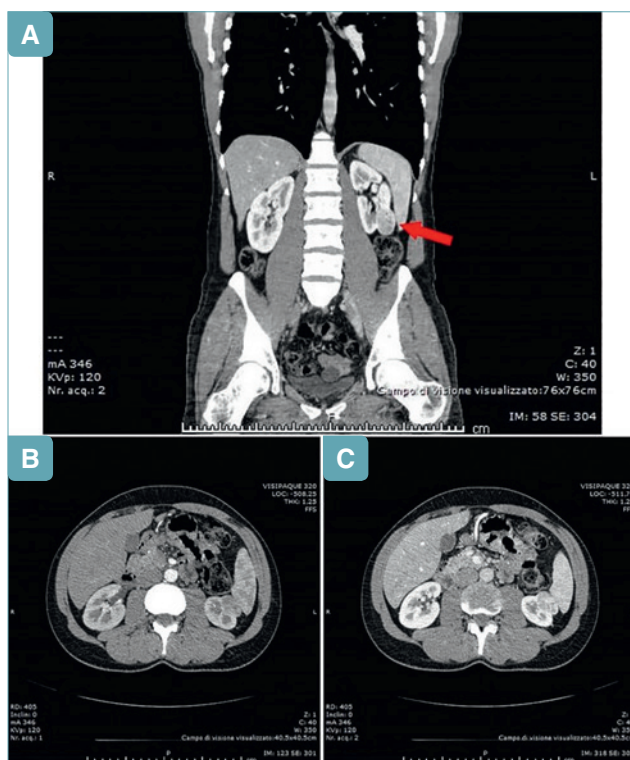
a-c) Computed tomography (CT) with Contrast Media (Visipaque 320). Lower left renal pole solid exophytic mass (red arrow). The neoplasm was 3.5x2.0 cm in size with 3.8 cm longitudinal diameter with non-homogeneous contrast enhancement (a; b. arterial phase image; c. portal-venous phase image).
